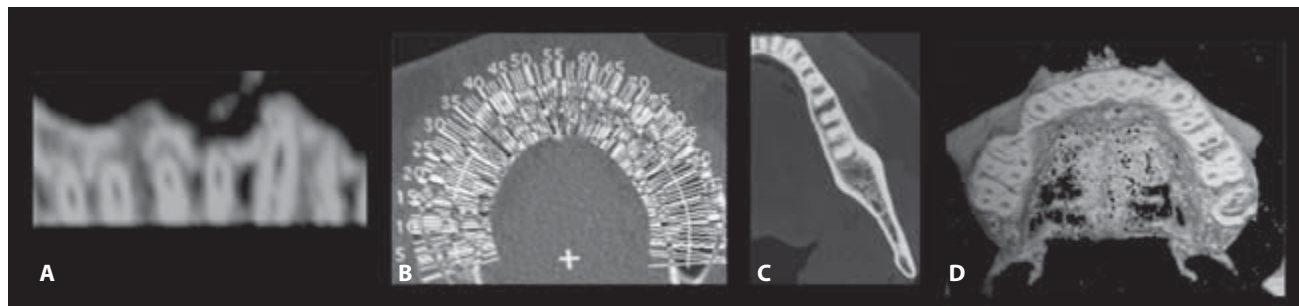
Different views of a computerized tomography (CT) of the maxilla and mandible.
